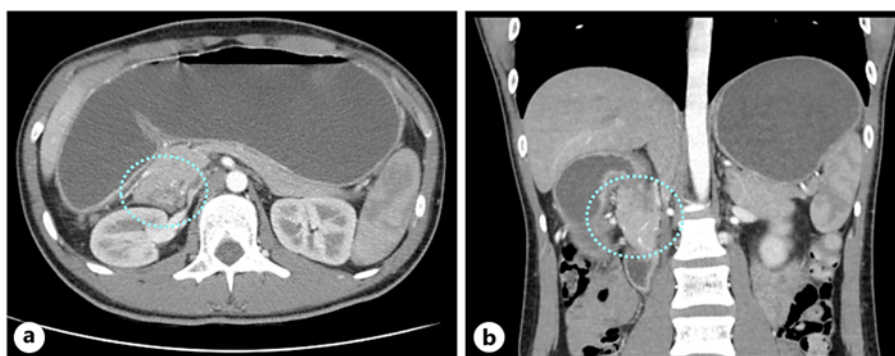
CT scan – axial (a) and coronal (b) planes – showing gastric distension and stenosis of the second portion of the duodenum with abnormal pancreatic head tissue wrapping the descending part of the duodenum (dotted blue circle). CT, computed tomography.
